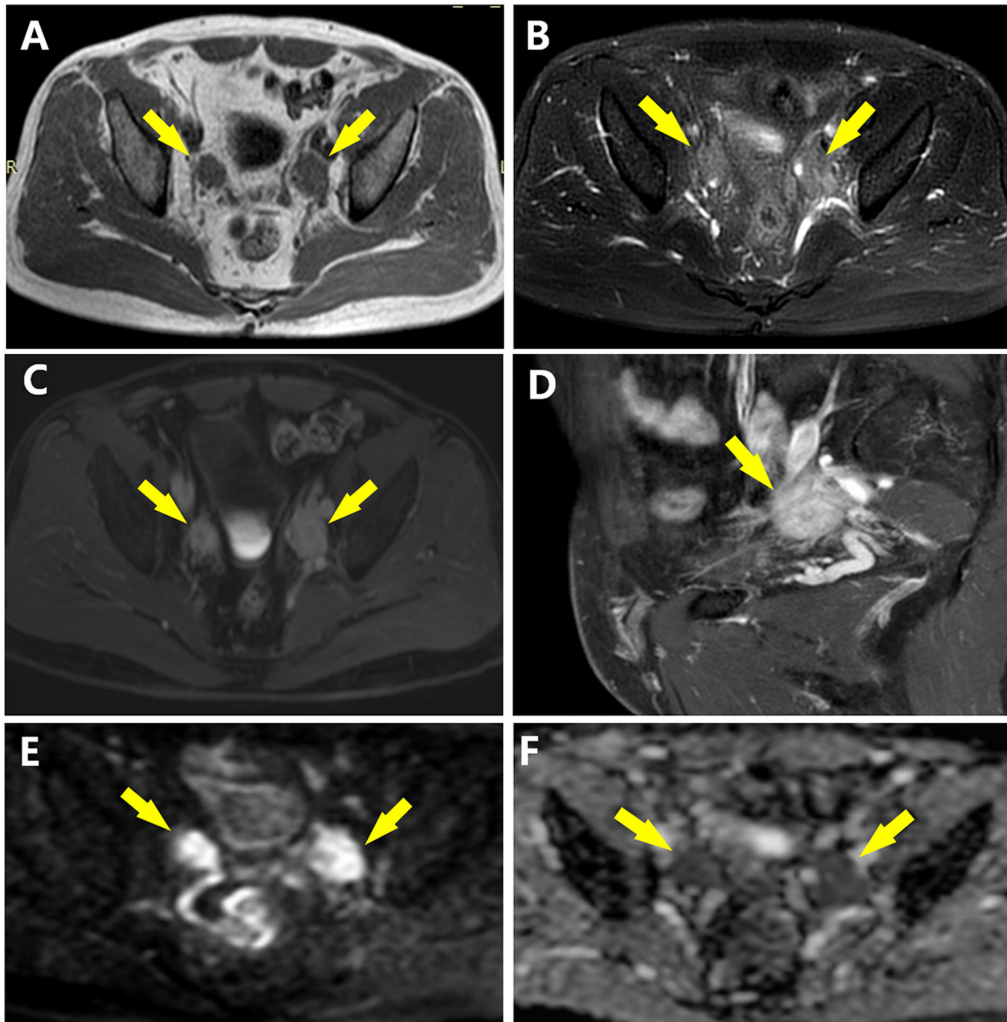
Imaging presentation of a 55-year-old male patient with IgG4-related retroperitoneal disease. In the axial (A) T1WI and (B) T2WI magnetic resonance imaging, bilateral lumpy soft tissue masses around the lower ureter are visible, the border is clear, the contour is not polished, T1WI has equal signal intensity and T2WI has equal or slightly higher signal intensity. On (C) T1WI axial enhanced and (D) T1WI sagittal enhanced, the masses display as significantly enhanced. (E) On diffusion-weighted imaging, the masses were displayed with a high signal. (F) In the apparent diffusion coefficient image, the masses had a low signal. T1WI, T1-weighted imaging. Yellow arrows indicate the soft tissue masses.
